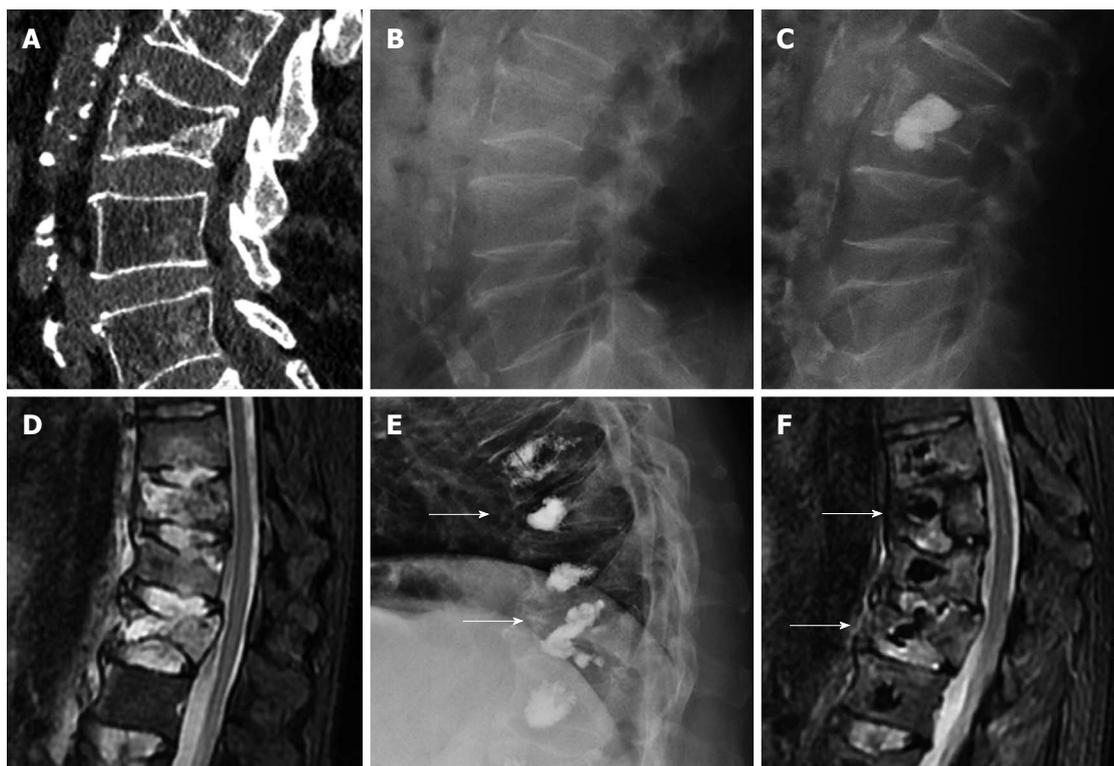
Sagittal computed tomography (A) a lateral radiography (B) showing fracture of L3 with intravertebral cyst (arrow), after Kyphoplasty (C) the ball of cement is not incorporated to the instable vertebral fracture, sagittal STIR image showing multiple thoracolumbar fractures with edema (D), treated with vertebroplasty, the cement do not stabilized the fracture of T10 and T12 (arrows) with persistent edema 6 mo after the procedure (E, F).
